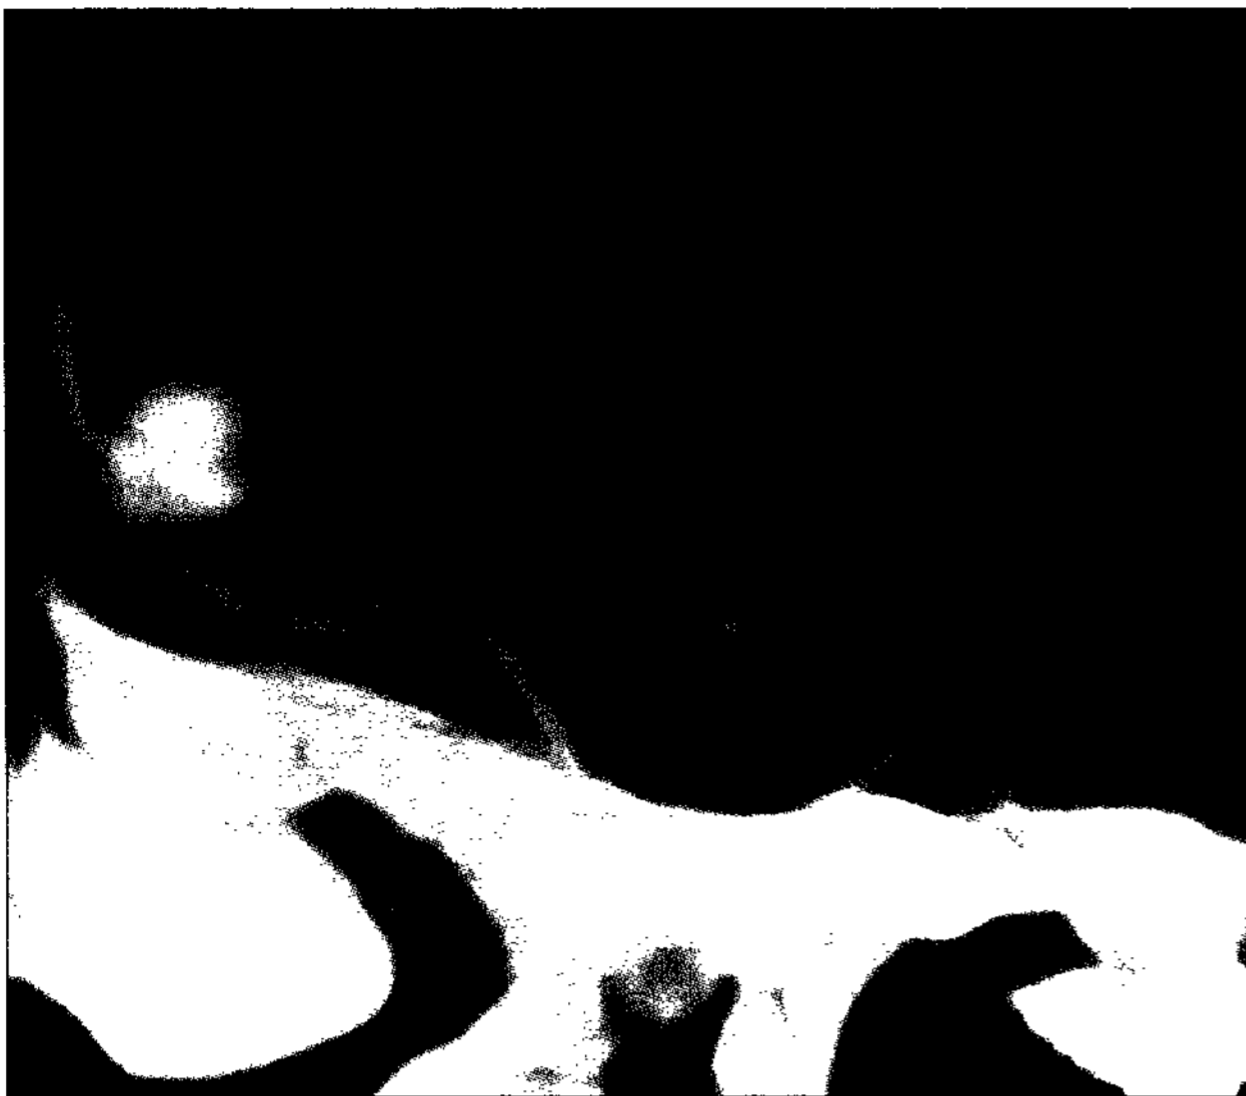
Three-dimensional computed tomography angiography revealing a cerebral aneurysm(9×7mm) arising from the left middle cerebral artery.
